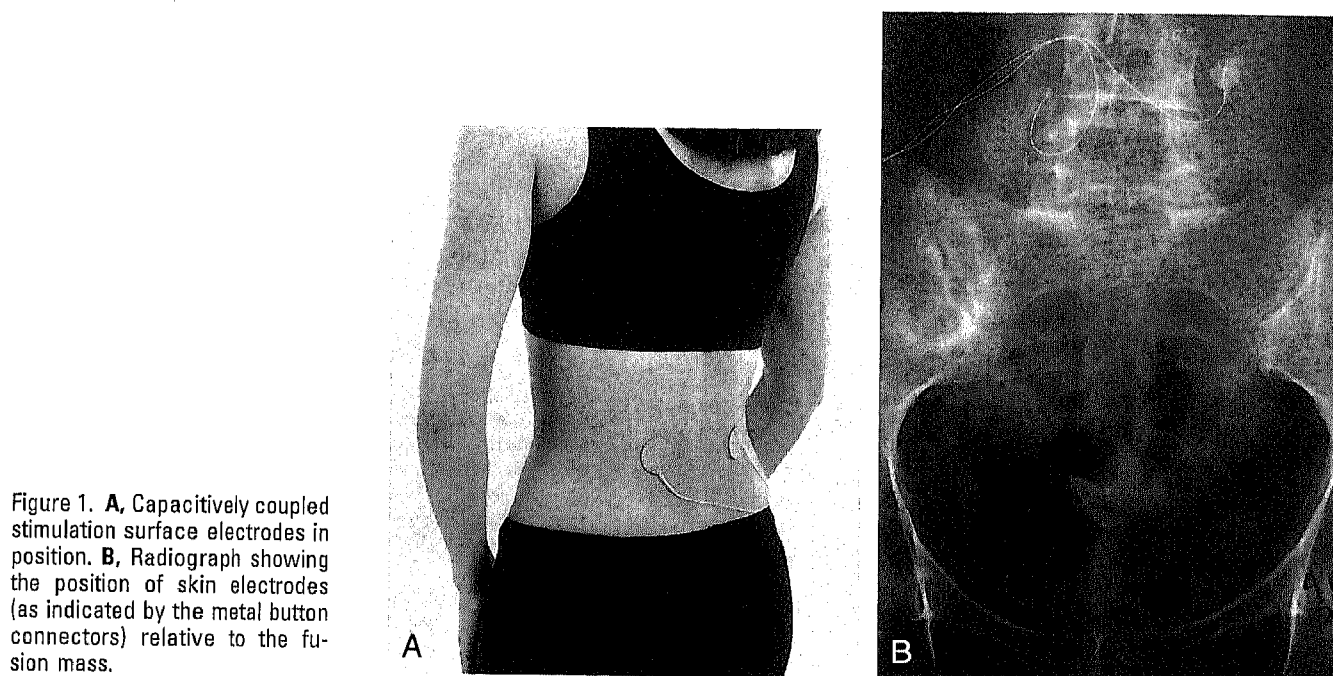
A, Capacitively coupled stimulation surface electrodes in position. B, Radiograph showing the position of skin electrodes (as indicated by the metal button connectors) relative to the fusion mass.
